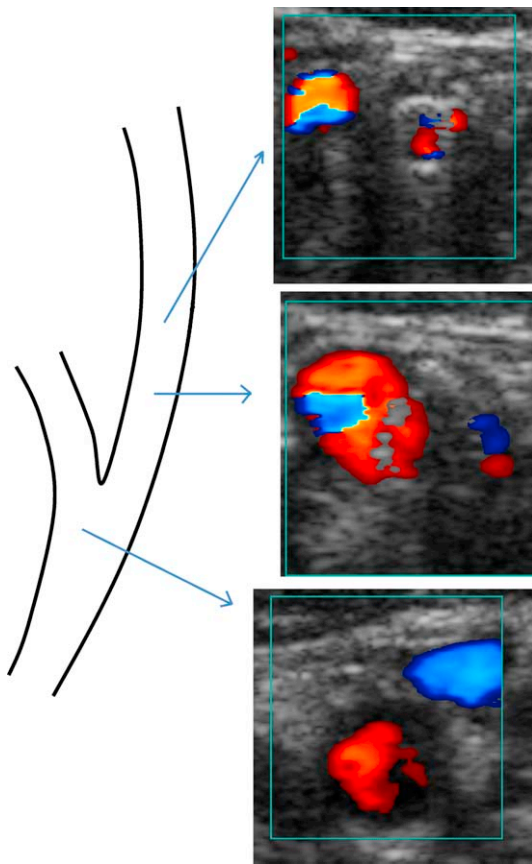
Post Carotid ultrasound. Flow in the right carotid artery did not appear centered in the vessel lumen.
